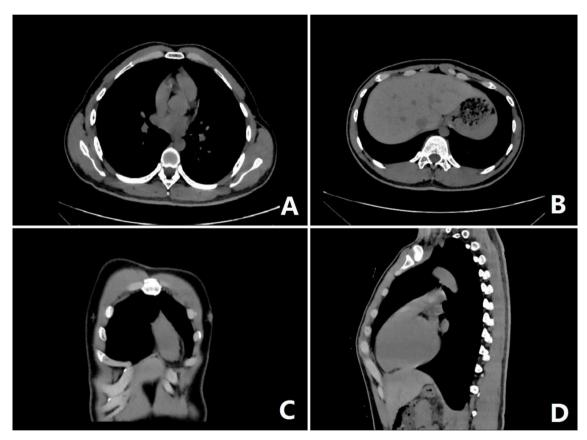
Preoperative chest wall CT images. A, Sectional image of the middle part of the chest wall; B, Sectional image of the lower part of the chest wall; C, Coronal image of chest wall; D, Sagittal image of chest wall.
